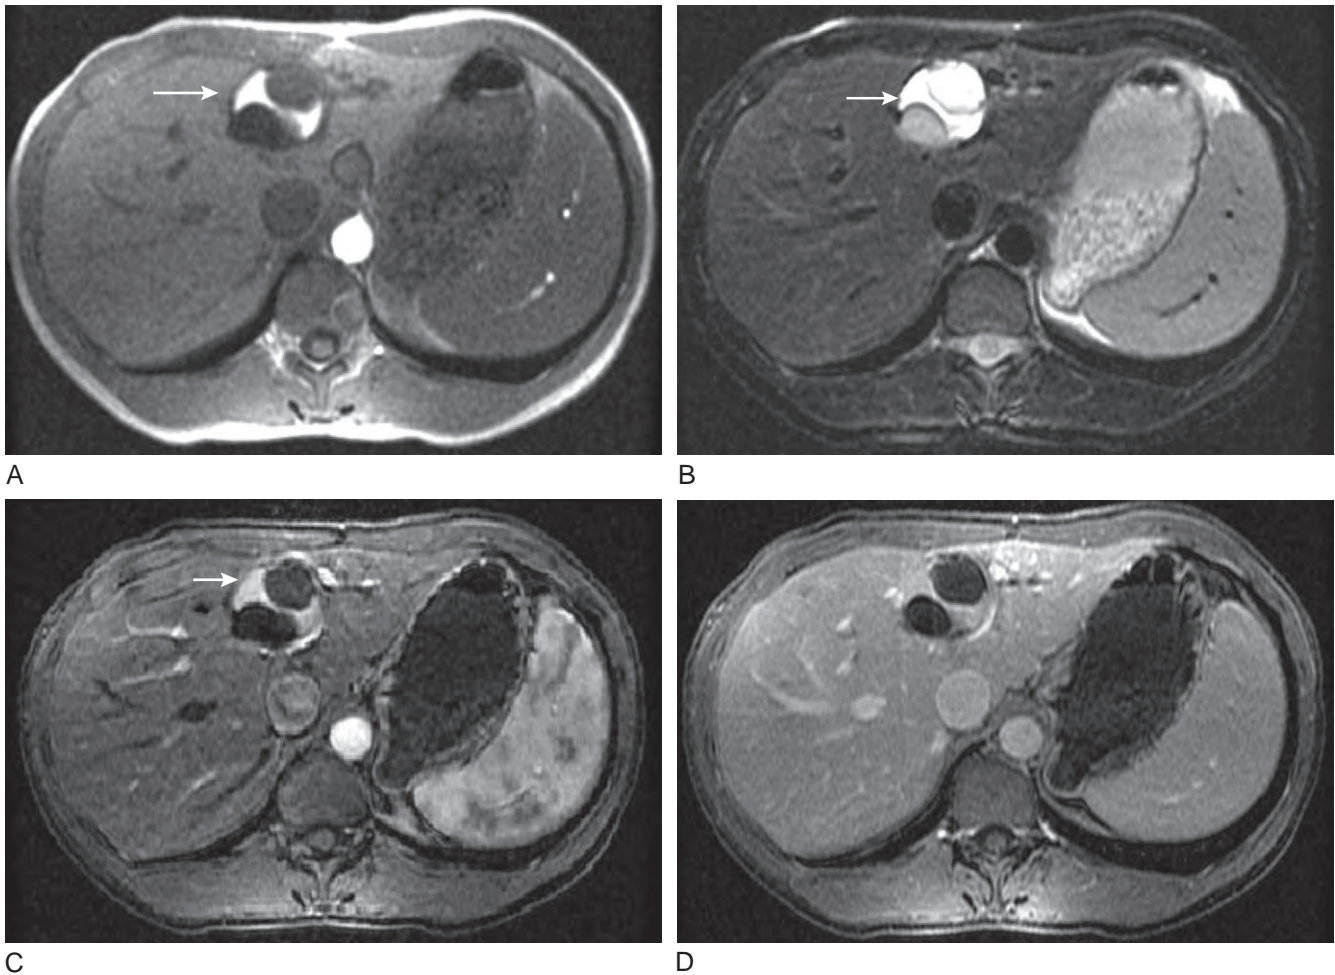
Hepatobiliary mucinous cystadenoma with ovarian stroma. Transverse T1-weighted (A) and T2-weighted (B) images of the liver show a complex multilocular mass in the left lobe (*arrows*). The mucinous content of the mass has mixed high and low signal intensity on T1-weighted imaging and high and intermediate signal intensity on T2-weighted imaging, respectively. The mass (*arrows*) does not enhance on early (C) or delayed (D) postgadolinium imaging.
